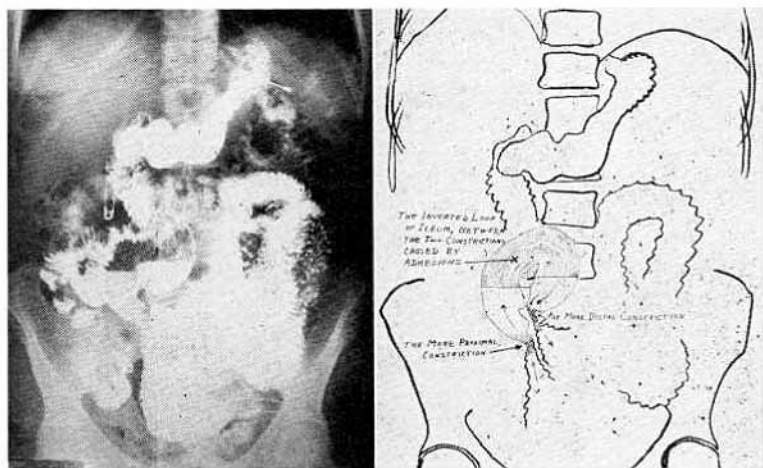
Case I. Ventral projection five days after passage of Miller-Abbott tube and three days after removal of same. Barium administered by mouth reveals normal stomach and duodenum, and a normal small intestine down to the points of obstruction in the ileum, previously demonstrated. At operation three weeks later, the findings were exactly as demonstrated in this roentgenogram. A somewhat dilated loop of ileum, inverted, constituted a sort of volvulus between points of narrowing, caused by adhesions to the ventral abdominal wall. As shown by the earlier roentgenograms, it was into this loop of ileum that the balloon of the Miller-Abbott tube became inserted. The balloon passed the proximal obstruction, but never passed through the distal obstruction.
